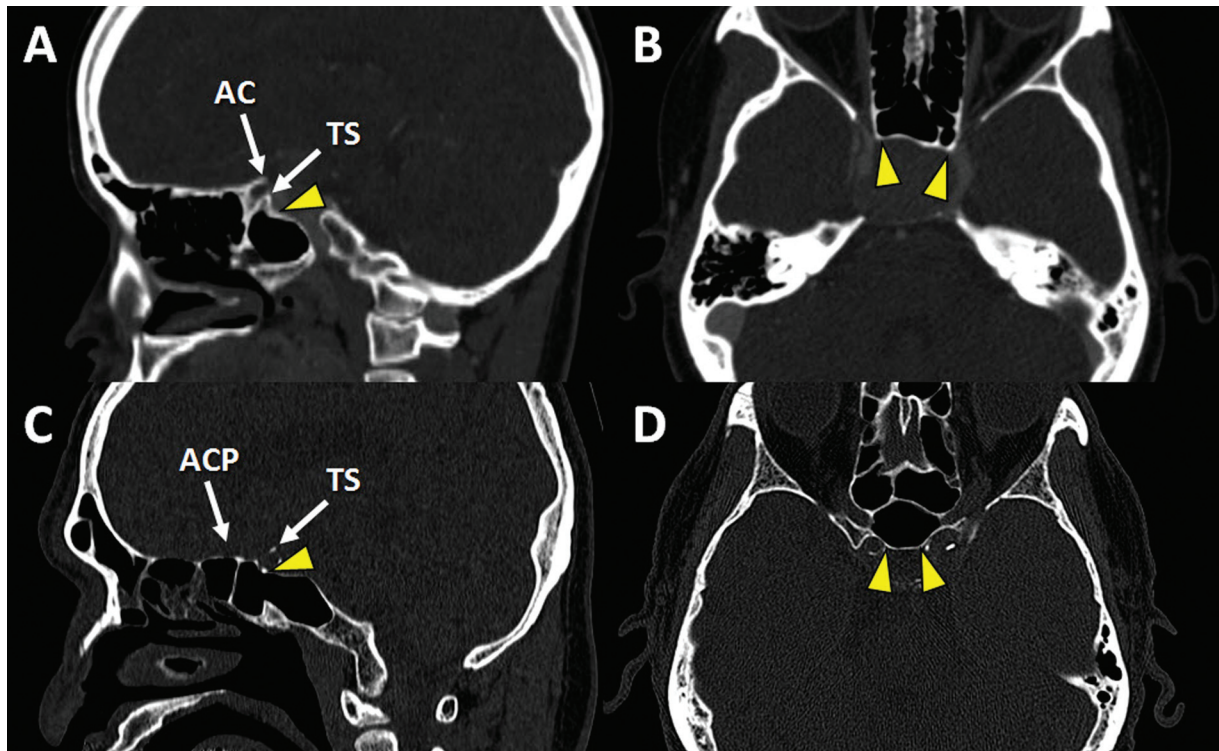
Bone window of cranial computed tomography showing the absence of middle clinoid process (arrowhead) in a patient with a pituitary adenoma in sagittal (A) and axial planes (B), and in a patient without sellar lesion in sagittal (C) and axial planes (D). ACP, anterior clinoid process; TS, tuberculum sellae.
